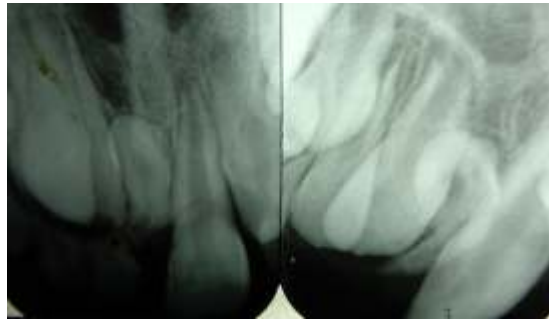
IOPA radiographs taken using SLOB rule to determine position of mesiodens
